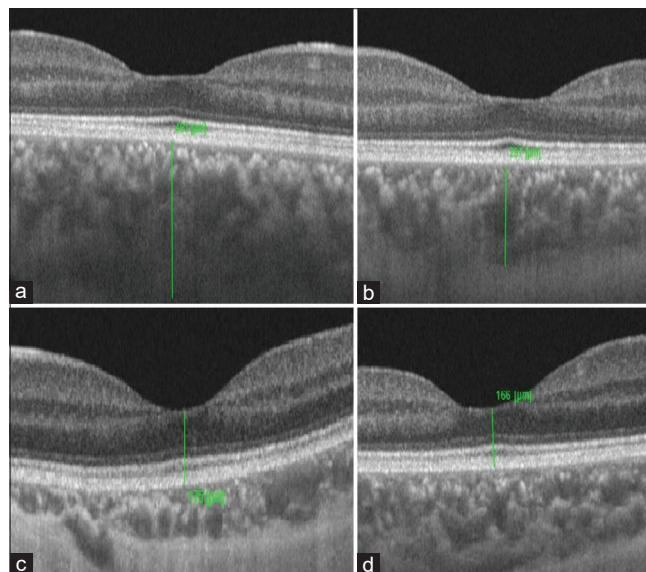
Comparison of choroidal thickness (CT) and macular thickness (MT) between amblyopic and fellow normal eyes at the time of presentation. (a and b) CT of amblyopic and fellow normal eyes, respectively, (c and d) MT of amblyopic and fellow normal eyes, respectively
